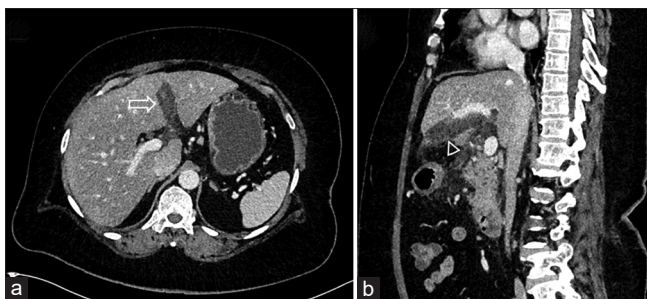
Contrast-enhanced axial (a) and sagittal (b) CT images show bulky and hypodense falciform ligament with associated fat stranding (open white arrow in a and open arrowhead in b). The left portal vein is normally opacified. CT: Computed tomography
